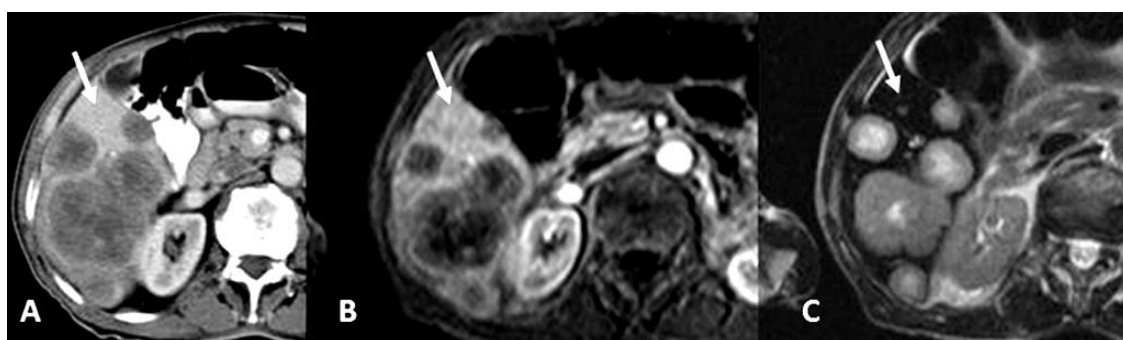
Images of multiple liver metastases from colorectal carcinoma accessed by (A) computed tomography, (B) gadobenate dimeglumine-enhanced MRI and (C) SPIONs-enhanced MRI. Using SPIONs (C) it is possible to detect small lesions with much more higher contrast (arrow). Adapted from [40].
